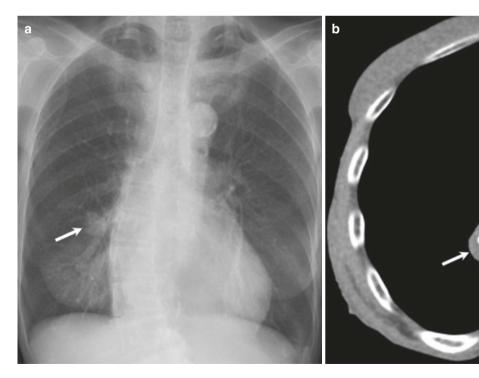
A 64-year-old female with hamartoma. (a) Frontal radiograph of chest shows a well-defined solitary pulmonary nodule projected over right lower zone (arrow). (b) Contrast-enhanced axial CT
